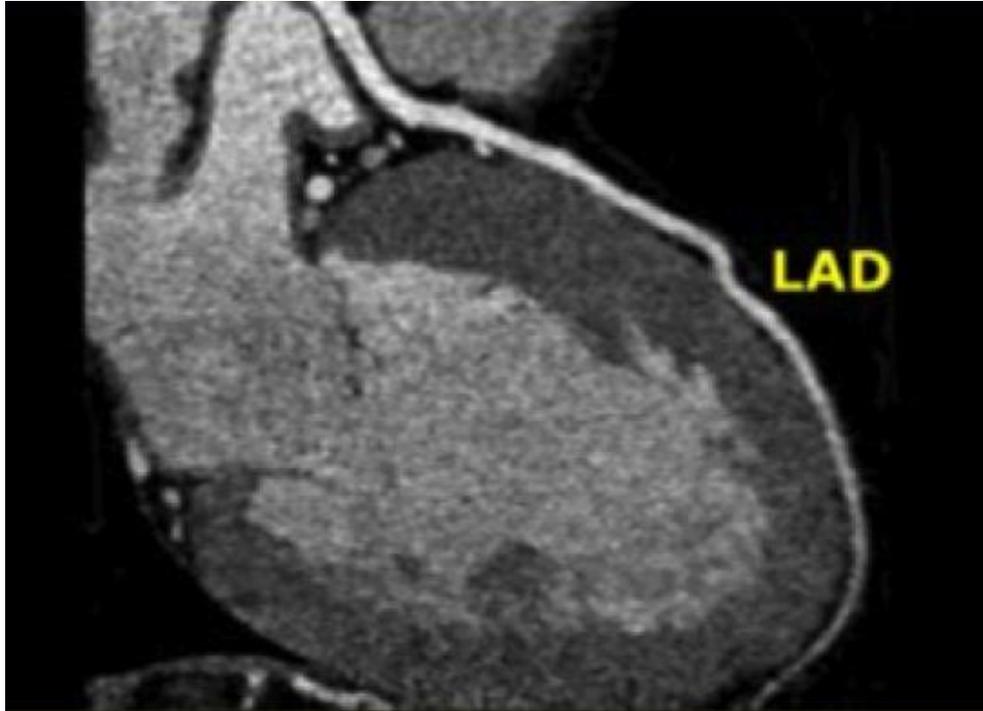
A CT image of the LAD in RAO projection
